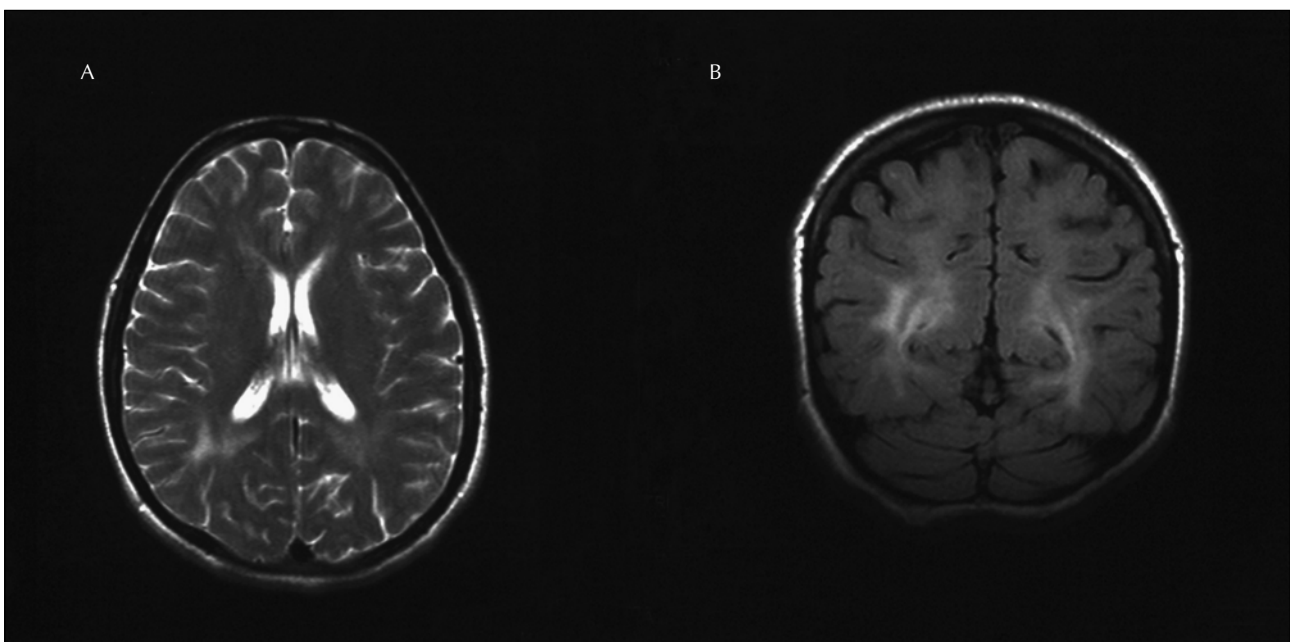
MRI scan of the brain, showing white matter involvement.
